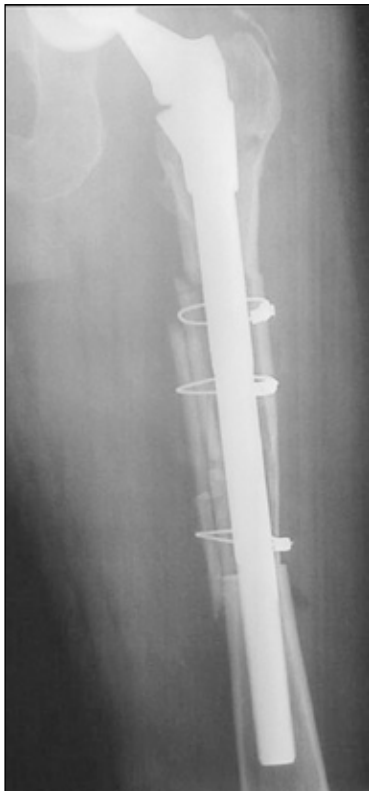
Anteroposterior radiograph of the left femur immediately following re-revision.
